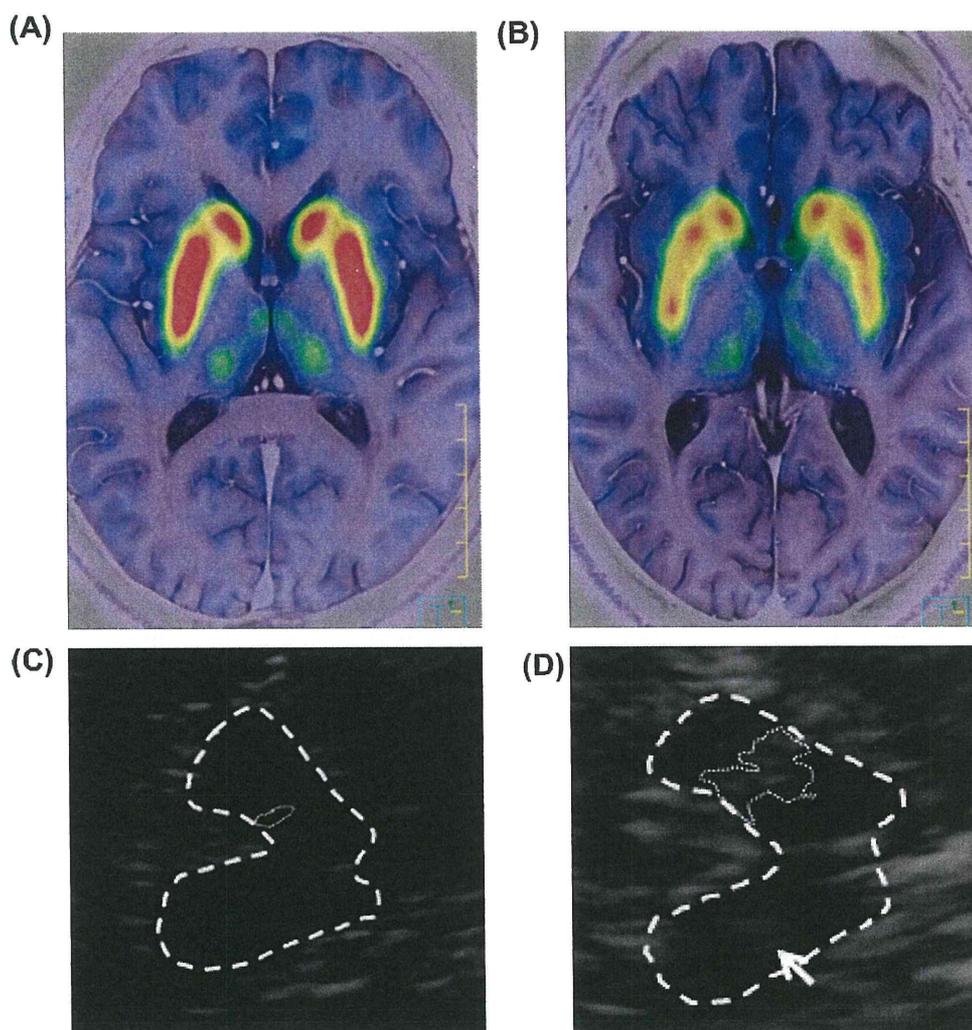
(A) 6-[¹⁸F] Fluoro-meta-tyrosine positron emission tomography (6-[¹⁸F]FMT PET) on magnetic resonance imaging (MRI). This demonstrates preserved dopamine terminals in the caudate and putamen in a healthy subject. (B) 6-[¹⁸F]FMT PET on MRI. This demonstrates patchy decreased dopamine terminals in the caudate and putamen in a patient with idiopathic rapid eye movement sleep behaviour disorder (iRBD). (C) Transcranial sonography (TCS) of bilateral substantia nigra (SN) hyperchogenicity in a healthy subject. The area of hyperchogenic SN signal within the hypo-echogenic crus cerebri is encircled on the ipsilateral side for planimetric measurement (0.10 cm²). (D) TCS of bilateral SN hyperchogenicity in a patient with iRBD. The area of the hyperchogenic SN signal within the hypo-echogenic crus cerebri is encircled on the ipsilateral side for planimetric measurement (0.44 cm²).
